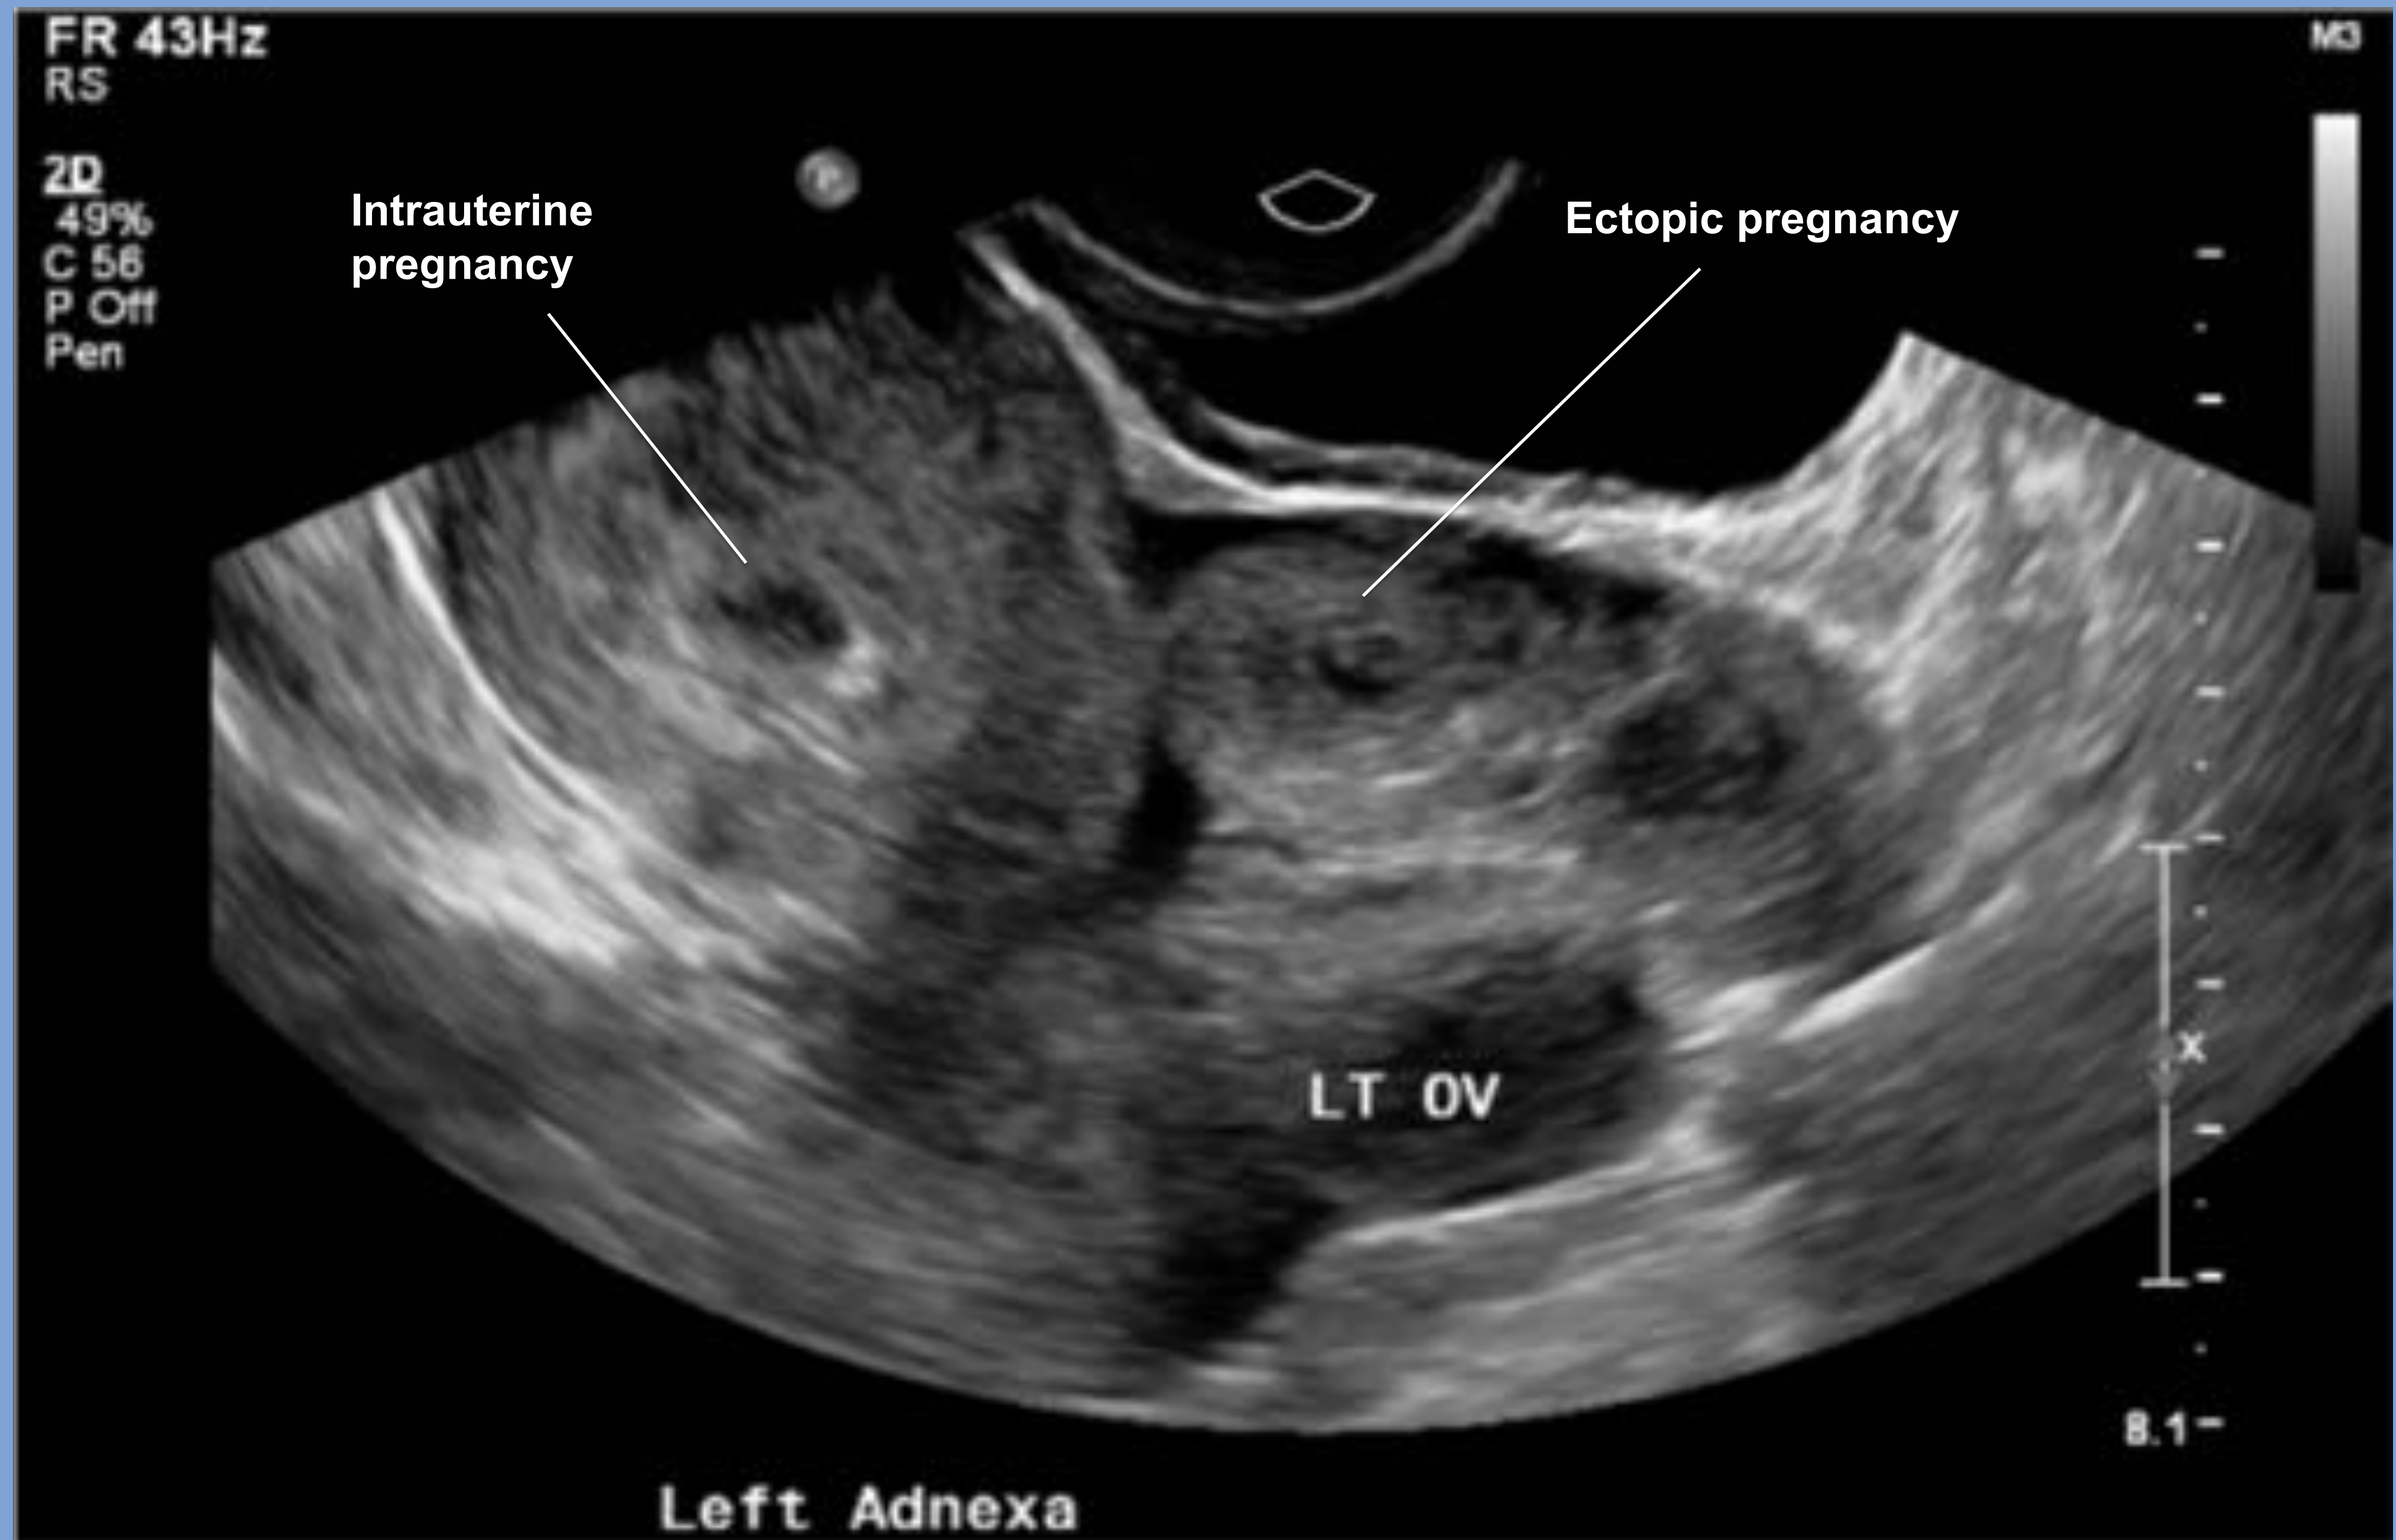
Ultrasound demonstrating left-sided ectopic pregnancy and intrauterine gestational sac
